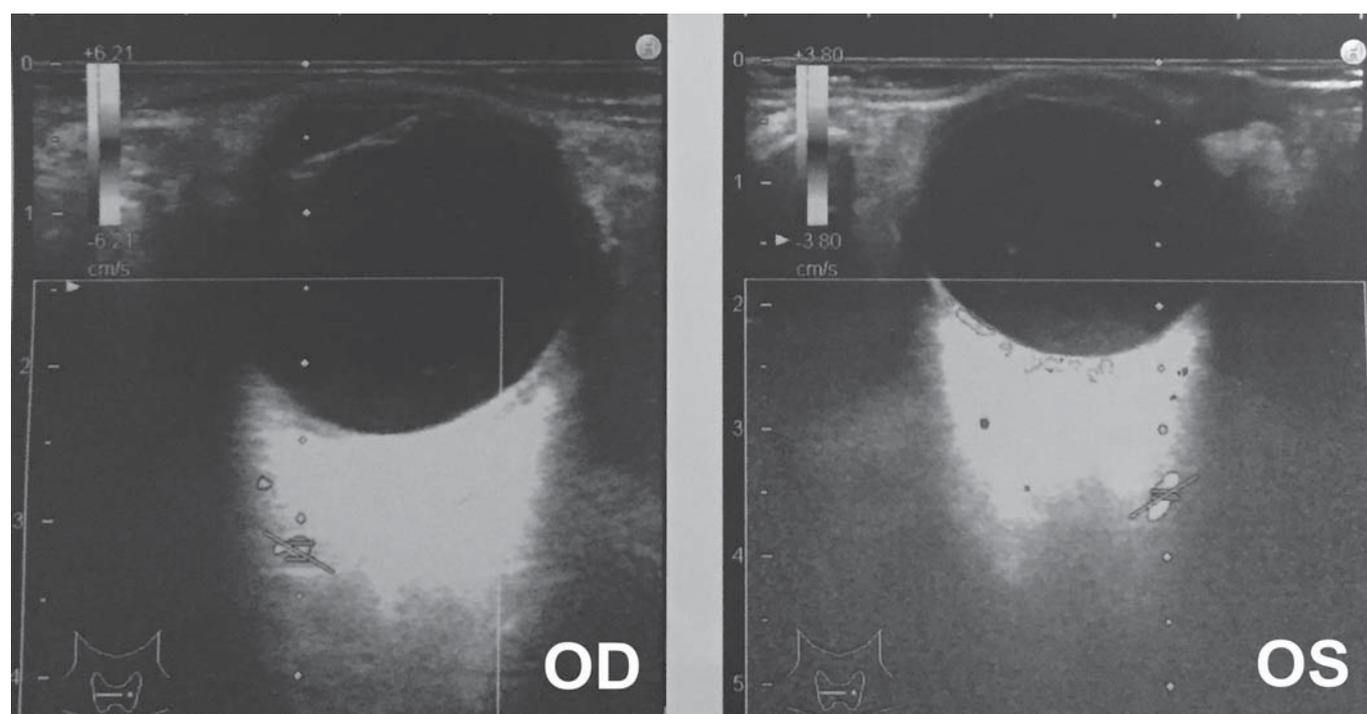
Initial B-mode ocular ultrasonography: there were no remarkable suprachoroidal effusion and choroidal detachment.
